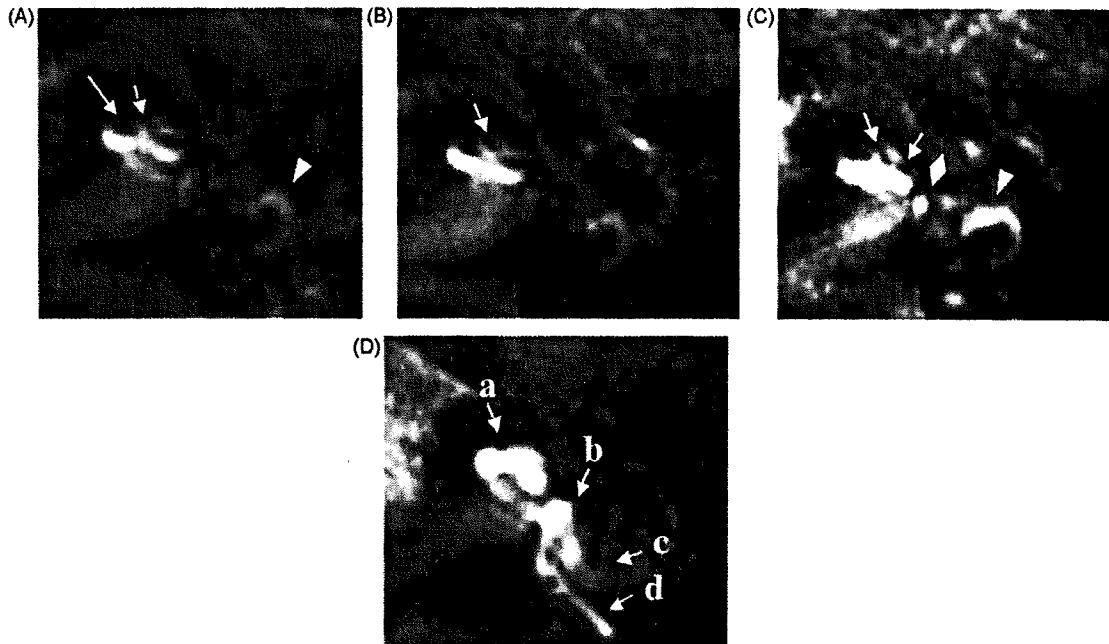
Three-dimensional fluid-attenuated inversion recovery magnetic resonance images on the axial plane. (A) The initial image shows endolymphatic space inside the perilymphatic space filled with the gadolinium in the lower (long arrow) and upper (short arrow) turns of the cochlea, and faintly visible gadolinium in the lateral semicircular canal (arrowhead). (B) The image at the second examination shows endolymphatic hydrops to a similar degree as that observed in the first MRI, and the hydrops in the upper turn of the cochlea is obvious (short arrow). (C) The image at the third examination shows reduced endolymphatic space in the cochlea (short arrows) and more strongly visible gadolinium in the vestibule (diamond) and the semicircular canal (arrowhead). (D) An image from a patient with acute sensorineural hearing loss with no endolymphatic hydrops is given as an example for comparison. (a) The cochlea, (b) the vestibule, and (c) the lateral and (d) posterior semicircular canals. The endolymphatic space is not clearly visible in this case.
